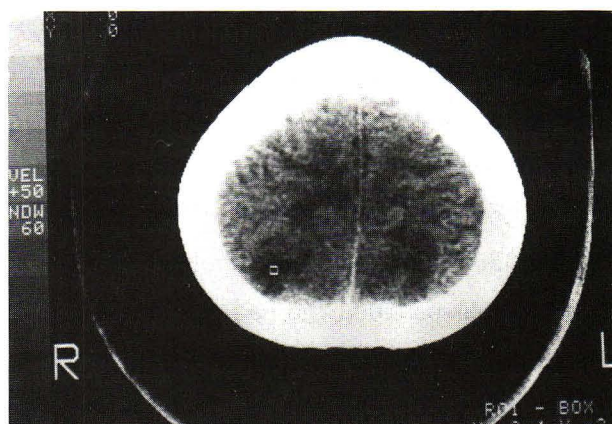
CT scan of case III, upper level, shows hypodensity in high parietal cortex and subcortical white matter.
